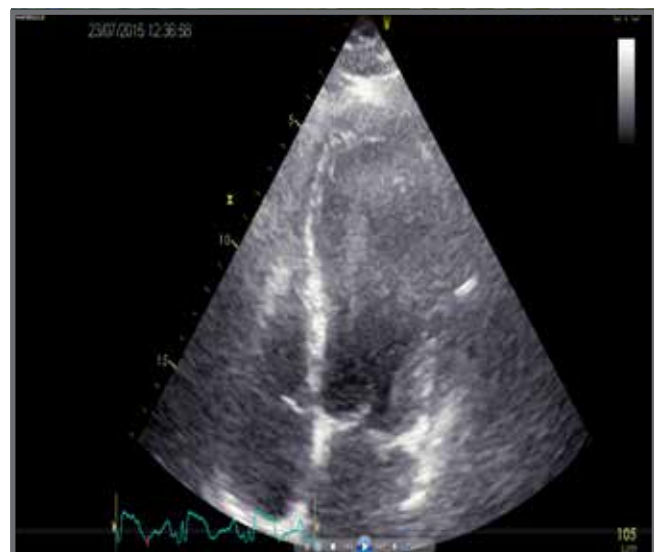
Spontaneous echocardiographic contrast in left ventricle
